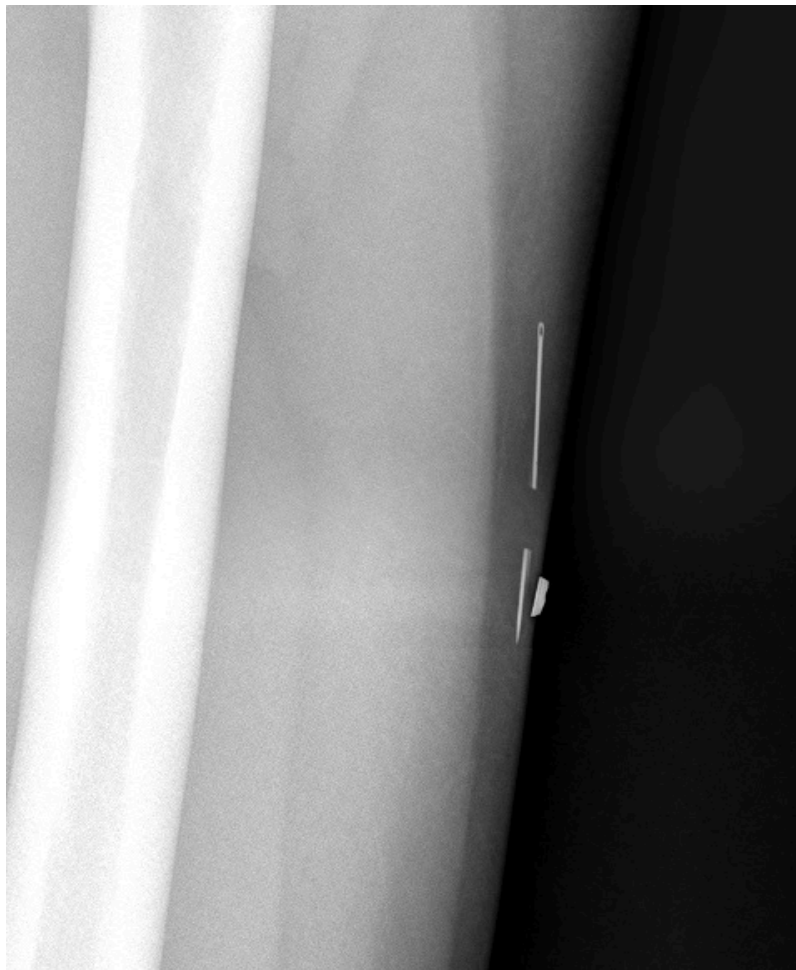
Lateral radiograph of the left thigh. Lead marker over skin where the foreign body was detected by palpation
